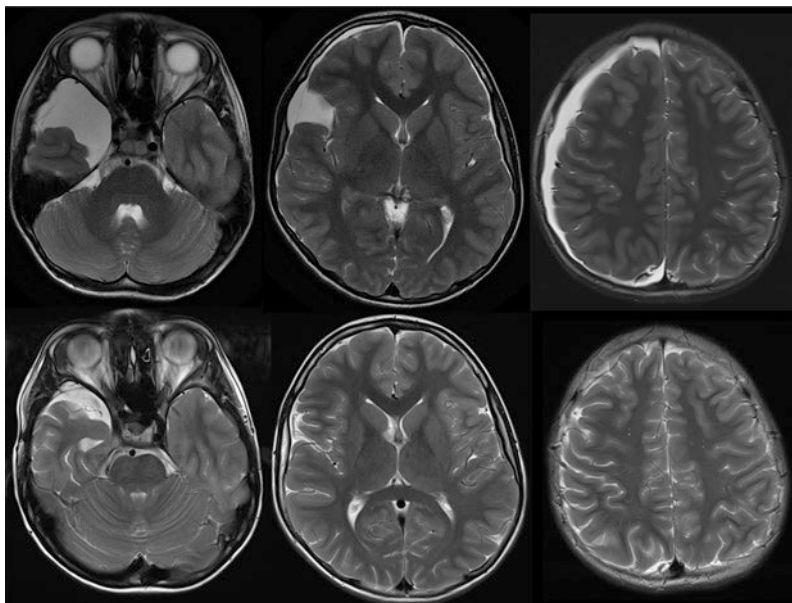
Axial T2-weighted MR images of a Galassi type II AC of a 12-year-old boy after spontaneous rupture with subdural hygroma formation (upper row). Notably, the cyst almost disappeared after microsurgical fenestration to the basal cisterns, and the subdural collection subsided (lower row)
